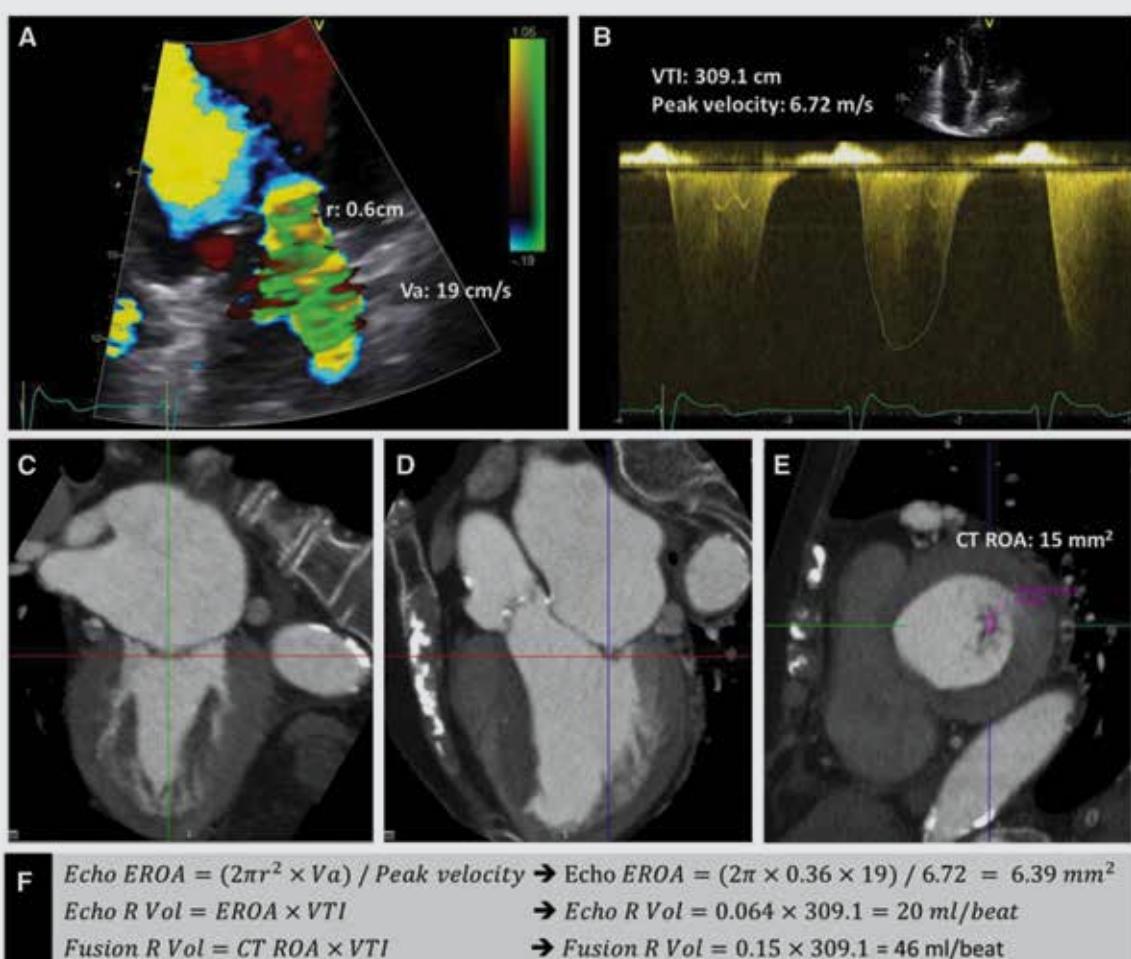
Integration of the Doppler echocardiography and computed tomography data to quantify mitral regurgitant volume. By echocardiography, the proximal isovelocity surface area method was used for the assessment of the effective regurgitant orifice area of the mitral regurgitation.(Panels A, B, and F) The velocity time integral of the magnetic resonance jet was assessed on the continuous wave Doppler images (Panel B). By aligning the multiplanar reformation planes on the multi-detector computed tomography data, a double oblique transverse plane parallel to the narrowest part of the mitral regurgitant orifice was reconstructed. The anatomical mitral regurgitant orifice area was measured by planimetry at this level (Panels C–E). The echocardiographic and integrated regurgitant volume of magnetic resonance were assessed by multiplying the echocardiographic effective regurgitant orifice area and the multi-detector computed tomography derived mitral regurgitant orifice area with the velocity time integral, respectively (Panel F). Reproduced with permission from van Rosendael *et al.*⁴²
